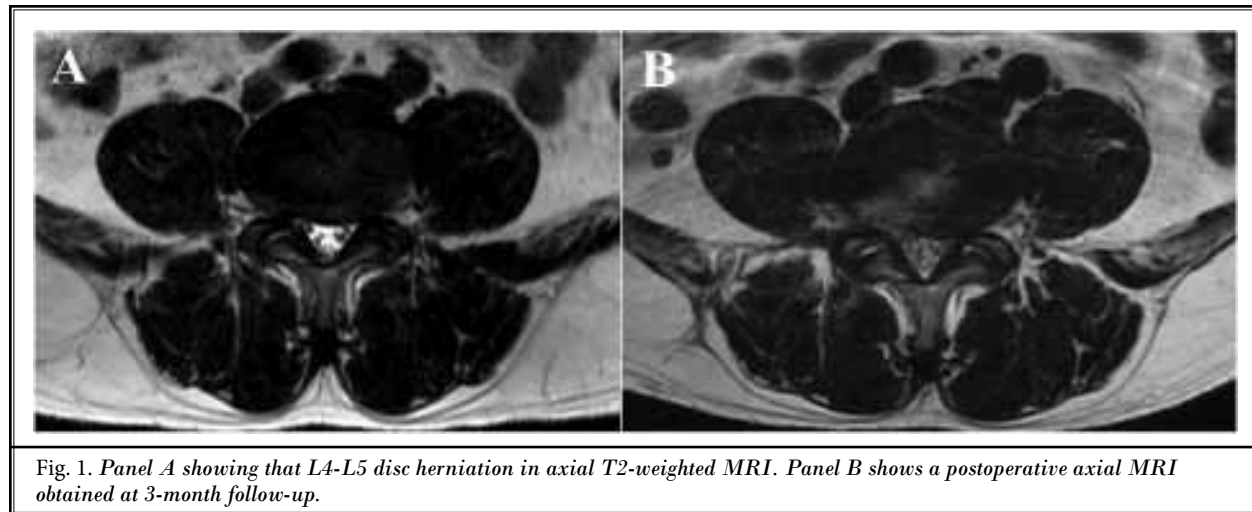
Panel A showing that L4-L5 disc herniation in axial T2-weighted MRI. Panel B shows a postoperative axial MRI obtained at 3-month follow-up.
